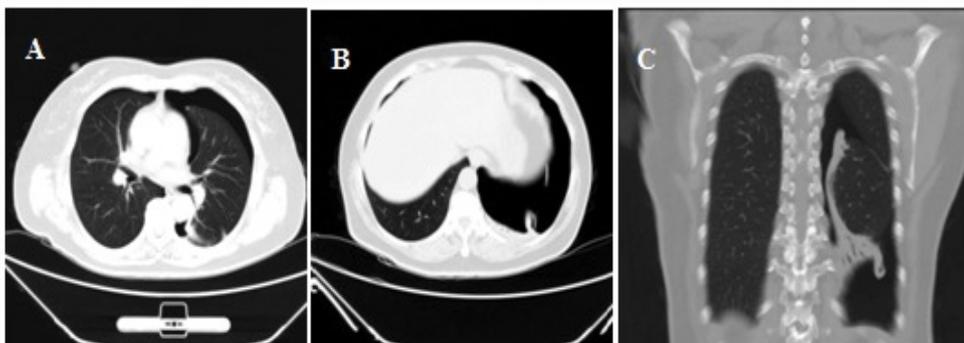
Reexamination of chest CT images 7 days after the first diagnosis. A and B are chest CT transverse images, and C is chest CT coronal image, it can be seen that the translucent area of the left thoracic cavity without lung texture was reduced, and the left lower lung was reexpanded. A, B also showed a small amount of left pleural effusion was roughly the same as before.
